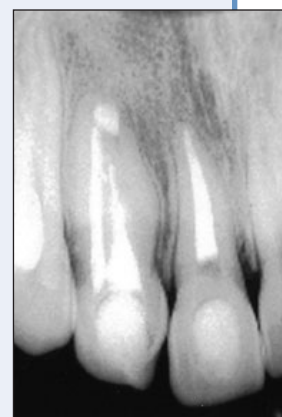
One year after treatment, the radiographic appearance of the periapical area is normal for both the central and lateral incisors.
